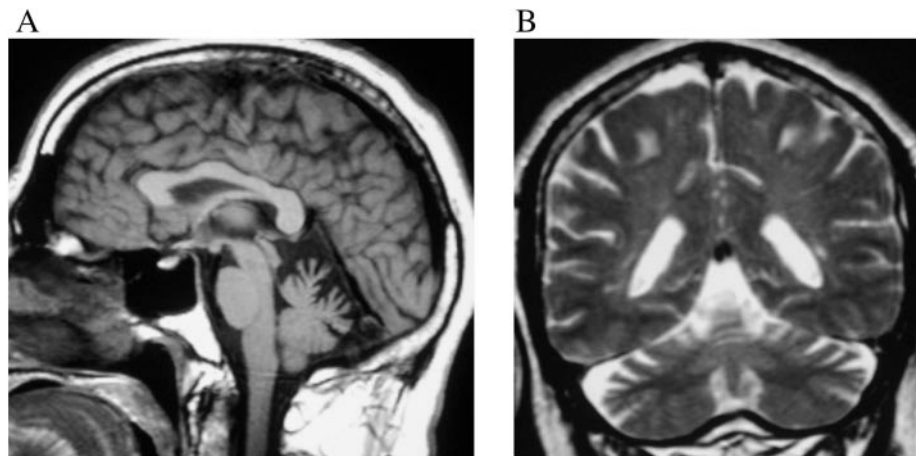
Brain MRI 1.5T of patient III-1. Panel (A) Midline sagittal T1-weighted image showing cerebellar atrophy, particularly evident in the superior vermis. The supratentorial compartment and the brainstem are normal. Panel (B) Coronal T2-weighted image showing atrophy of the cerebellar hemispheres with enlarged cortical sulci.
